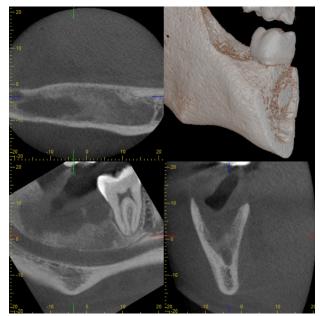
4-month follow-up CBCT.
